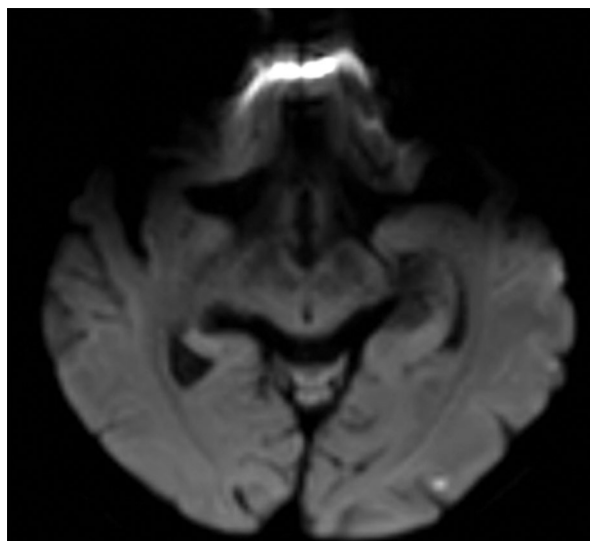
Magnetic resonance imaging of the head – in the left occipital lobe point areas of increased signal, corresponding to small, fresh ischemic changes
